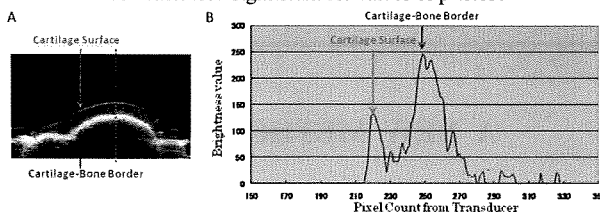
A) B-mode ultrasound image of the sample is shown. B) Line data acquired from the dotted line in the ultrasound image (A). Peak of the reflected ultrasound signal were defined as the surface and border of the tissue.
